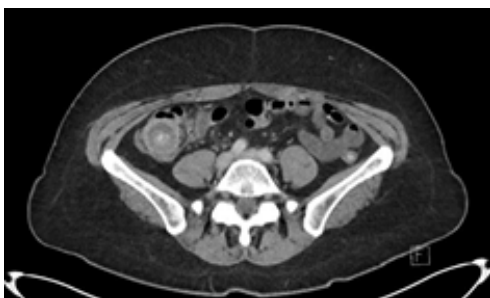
Axial CT image displaying a “target-like” sign, typical of appendiceal intussusception
